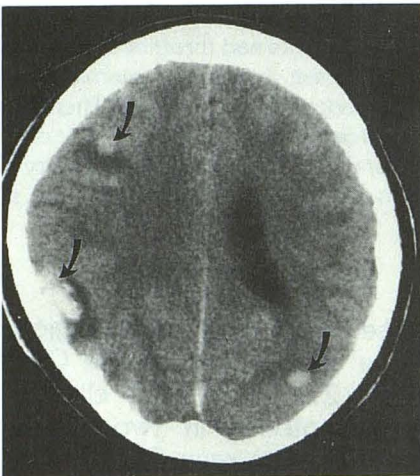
Case 2. Axial CT scan done 2.5 hours after clinical onset demonstrates sharply circumscribed hyperdense hematomas in the right middle temporal and inferior frontal gyri and the left inferior temporal gyrus (arrows).
